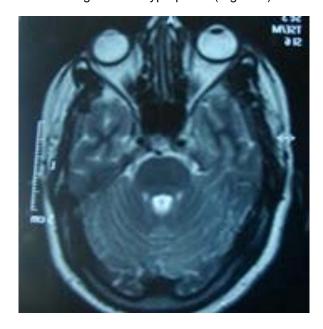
MRI section of pituitary area which revealed a normal scan, 10 year follow up.
